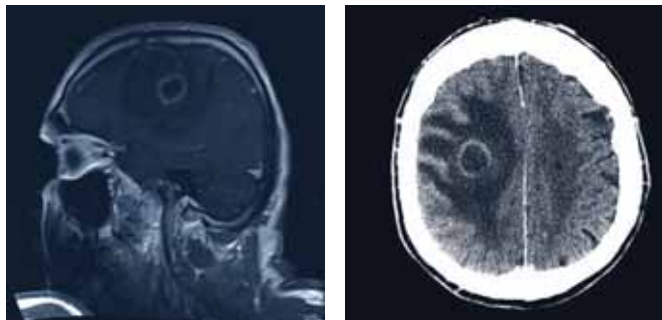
Post-contrast CT brain. The lesion shows rim enhancement in keeping with an abscess.
